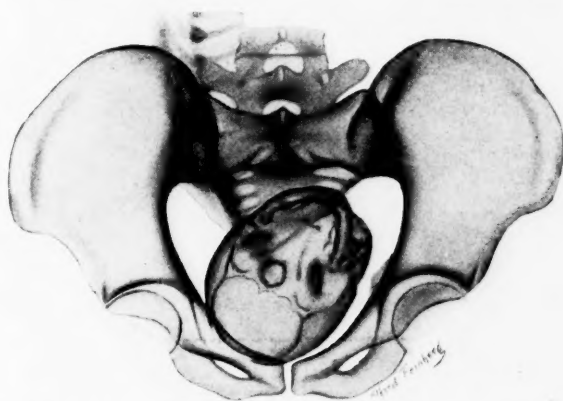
\*.—Second x-ray examination in labor (same case as Fig. 7). Head descending through soft part axis situated in the fore-pelvis. The head has rotated to the R. O. T.-R. O. A. position.
